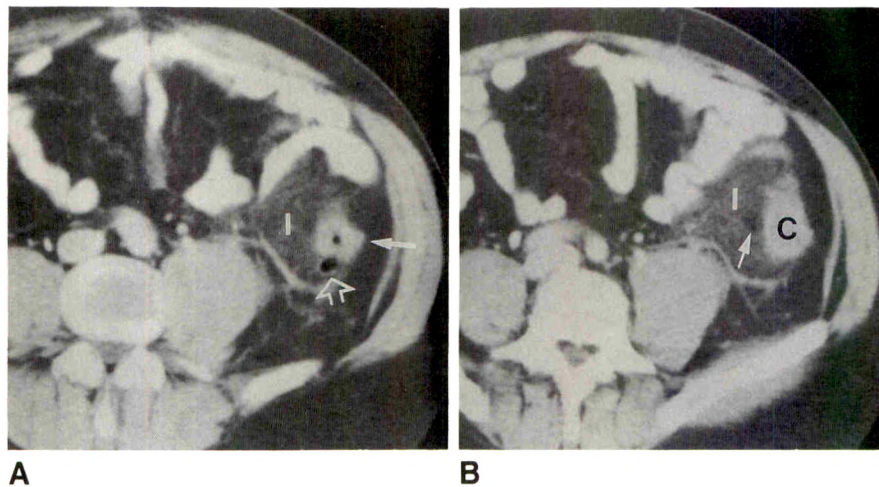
CT scans of acute diverticulitis of distal descending colon.
